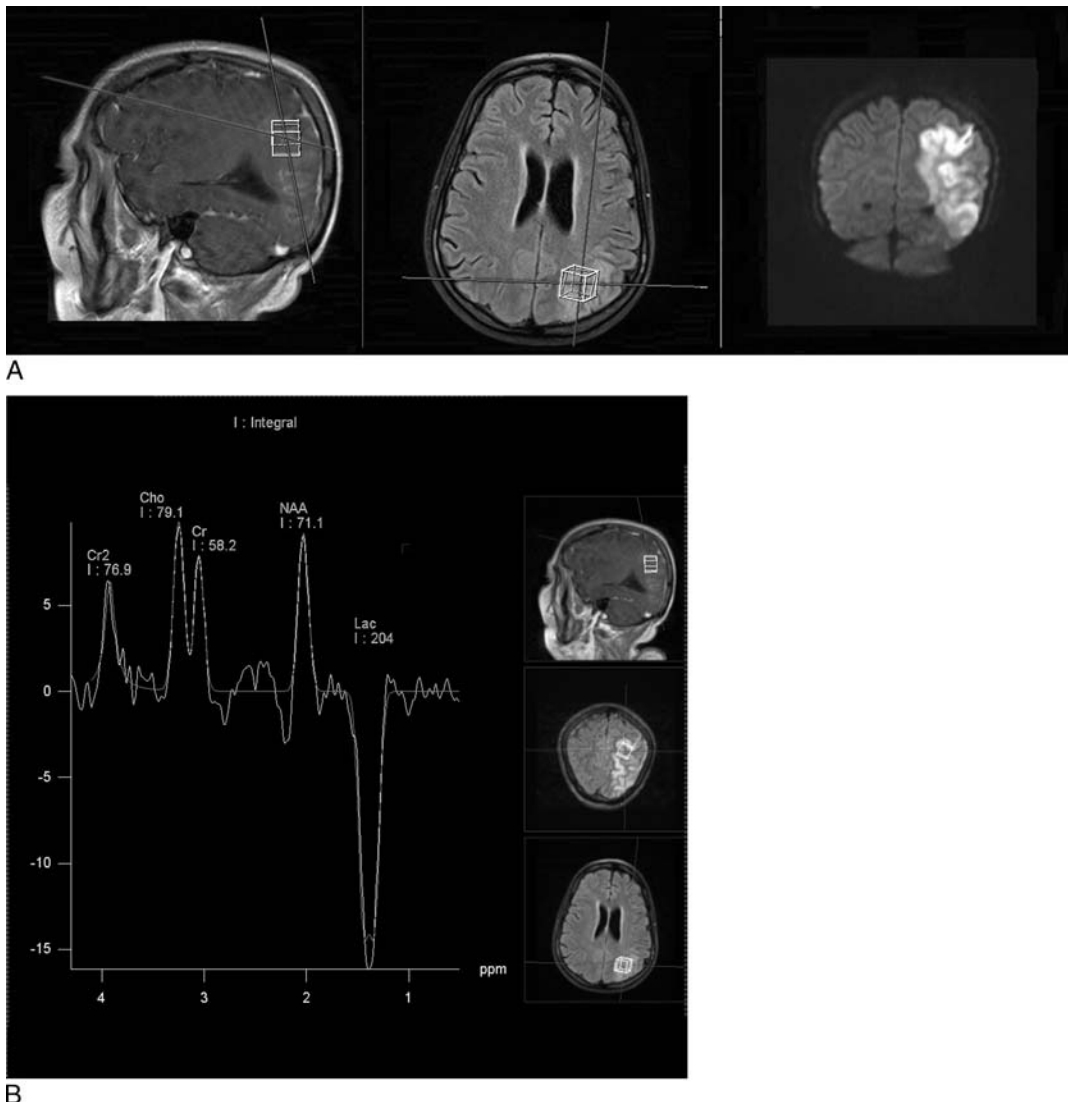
Magnetic resonance images (top row) and MRS (bottom row) of ischemia. Reduced NAA is depicted because of neuronal loss. The large lactate peak indicates anaerobic metabolism.
